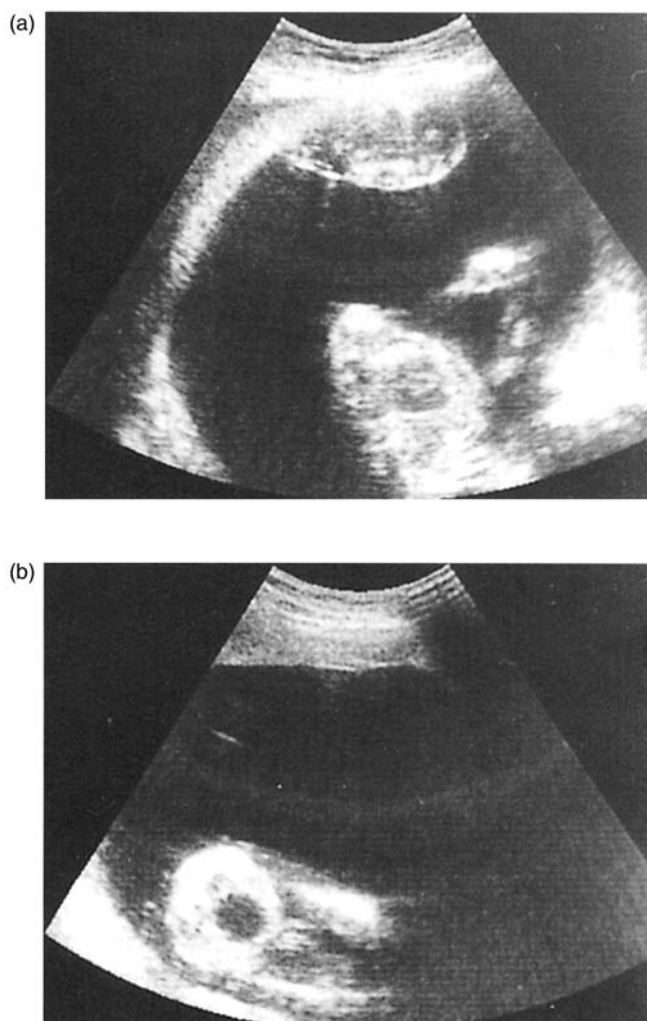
Ultrasound images demonstrating the features of TTS. (a) The 'stuck' donor fetus is in an anhydramniotic sac with no visible bladder. (b) The recipient fetus has a large bladder and polyhydramnios.
